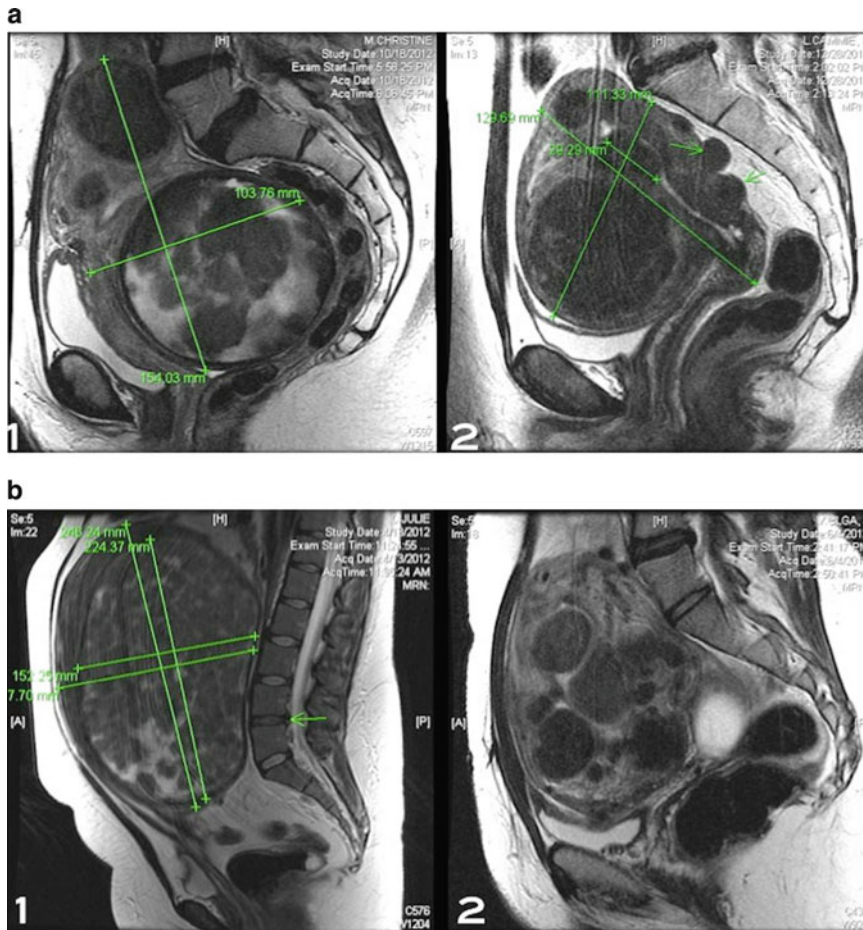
The laparoscopic threshold. (a): (1) and (2) show MRI images (T2-weighted sagittal projections) of typical surgical candidates for RM variant at our center. Myomas in the 1–10 cm range are effectively enucleated with this technique in our experience. (b): MRI images (T2-weighted
